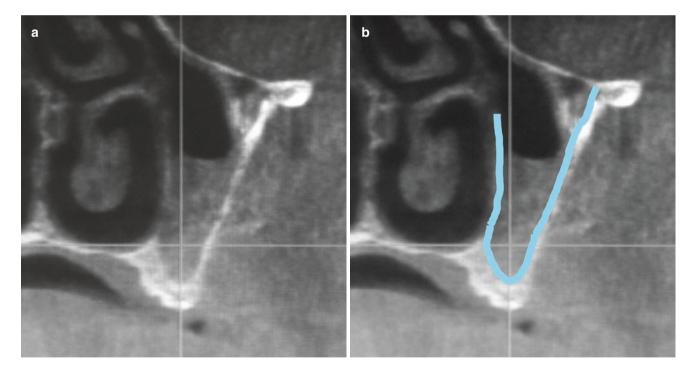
SFE with simultaneous cyst evacuation. (a) Preoperative tangential CBCT showing cystic lesion occupying two-thirds of the maxillary sinus volume. (b) *Blue line* depicts the Schneiderian membrane. (c) Cyst is approached via cranial opening that is placed high in the vestibule above the lesion (*arrow*). (d) Cyst content is aspirated. (e) SFE is performed via caudal opening. (f) Sinus mucosa is elevated. The band of the attached sinus mucosa between two openings (*arrows*) divides the sinus cavity from the empty space created
